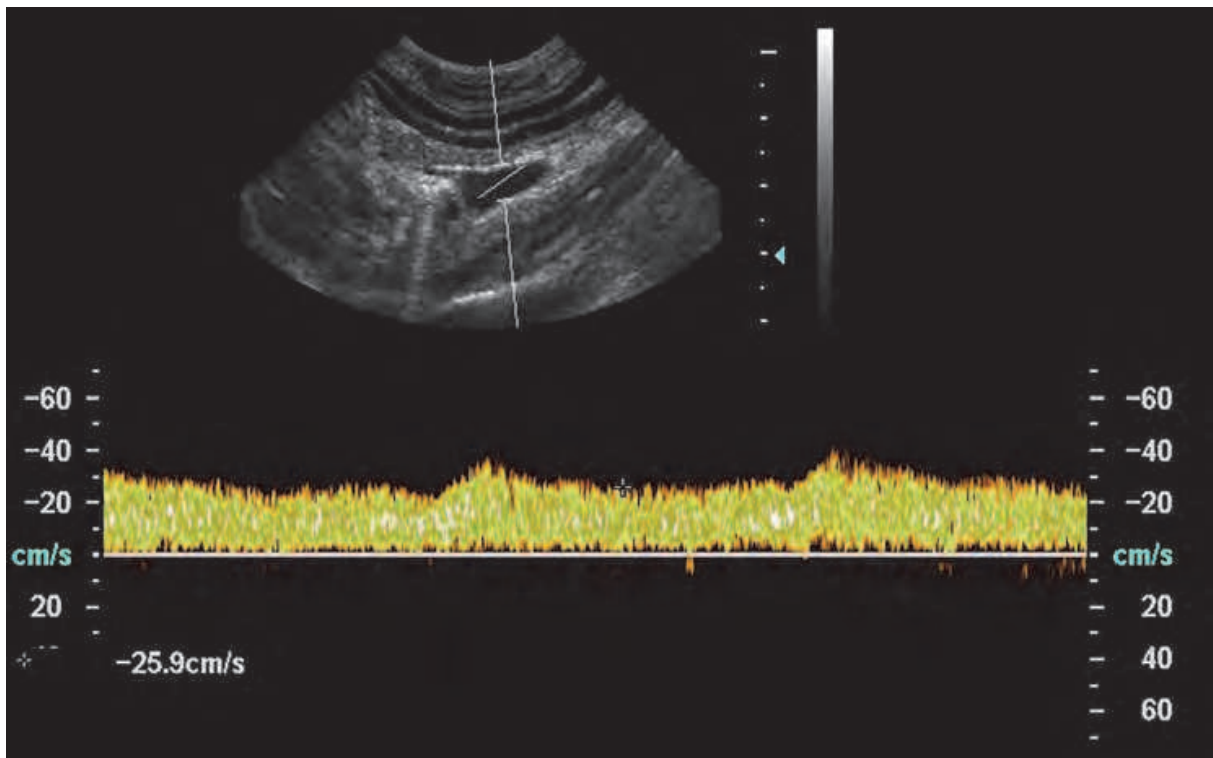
Pulsed wave Doppler in a normal portal vein. Using the sample volume the sonographer is able to define the studied volume, in this case it has a width of 4 mm.
